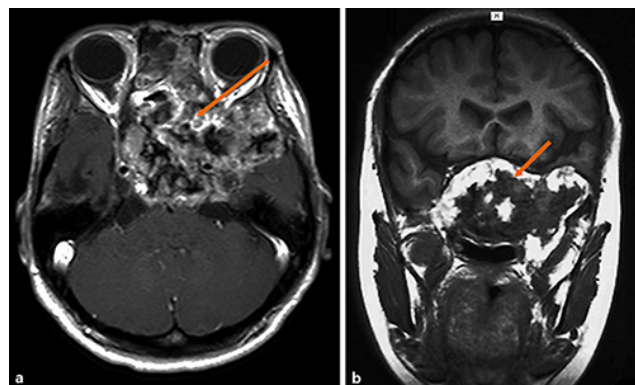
Horizontal (a) and frontal (b) oblique T1-weighted MRI images of the patient at age 23. The sphenoid sinus exhibits vestiges of a large cell tumour, according to the MRI.
